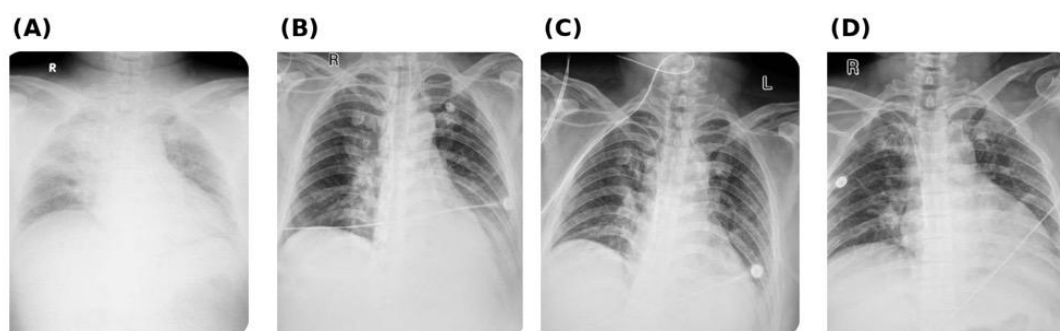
Serial anteroposterior chest radiographs of Case 2 following blunt-trauma pulmonary contusion complicated by hospital-acquired pneumonia. (A) Intensive-care day 1 with extensive bilateral opacification and near white-out (PaO₂/FiO₂ 72). (B) Day 4 with substantial aeration recovery (PaO₂/FiO₂ 134). (C) Day 9 with further clearing and residual basal changes (PaO₂/FiO₂ 176). (D) Day 11 with largely clear lung fields after liberation from invasive ventilation (PaO₂/FiO₂ 357). Only anatomical laterality markers are shown; the images carry no personal identifiers.
